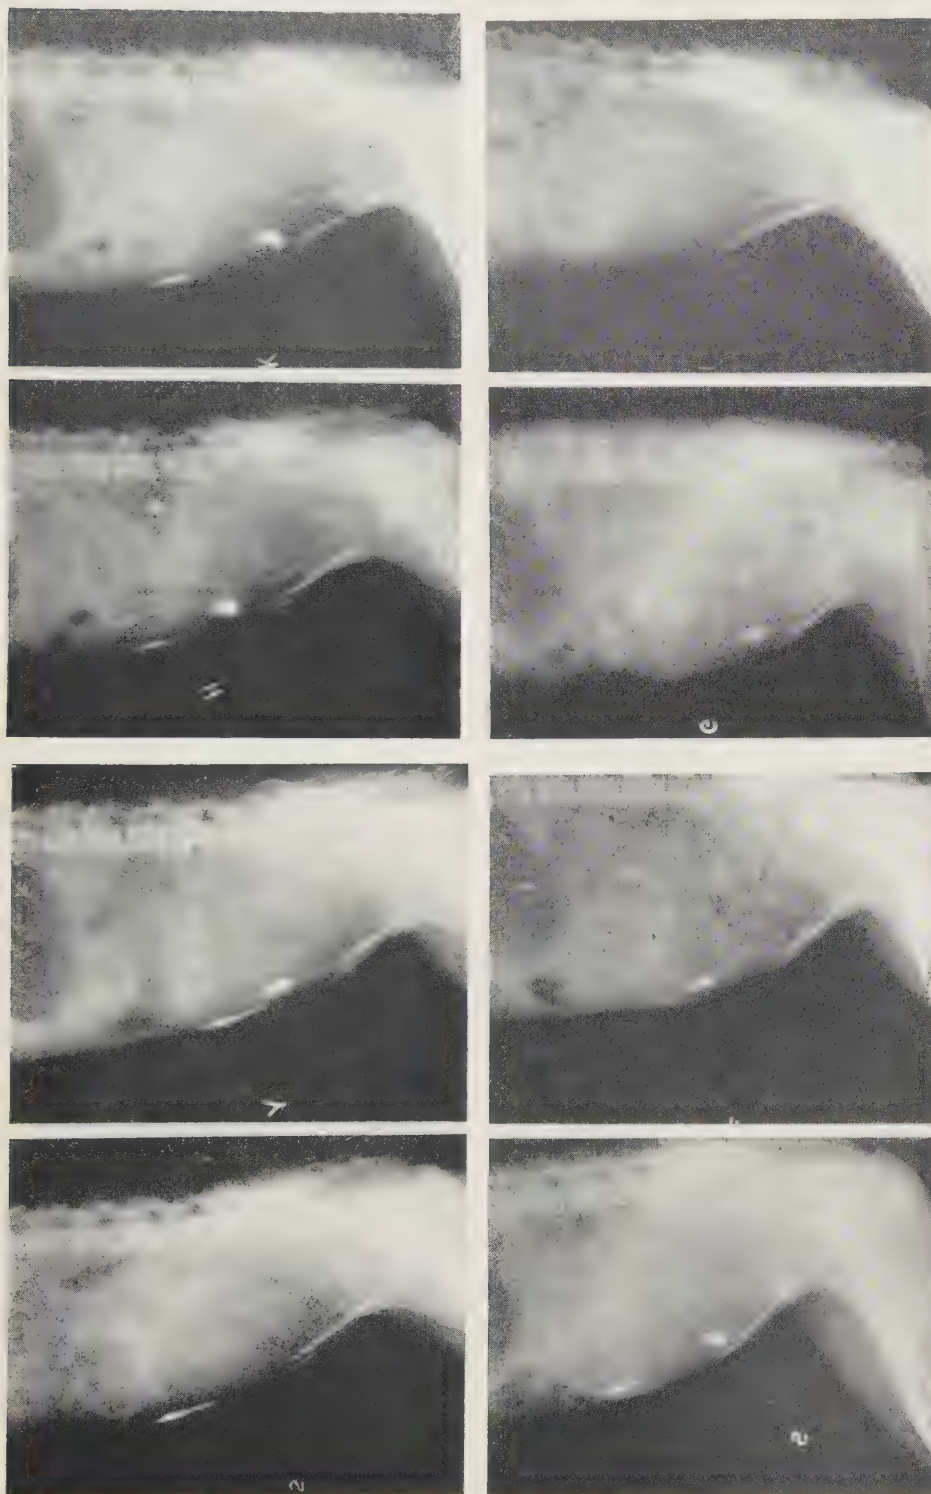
The x-ray marked (2) was taken immediately following injection of 1 cc of Diodrast into the anterior abdominal wall. The dye can be seen clearly lodged in the rectus muscle just below the level of the fetal head. The x-ray marked (Y) was taken 10 minutes later immediately following the injection of 1 cc of Diodrast into the myometrium. Succeeding x rays (H, K, S, P, E) were taken at regular intervals until both areas were cleared (1). In the series shown above clearance time for muscle was 25 minutes, and for uterus, 34 minutes. Duration of gestation was 106 days.
